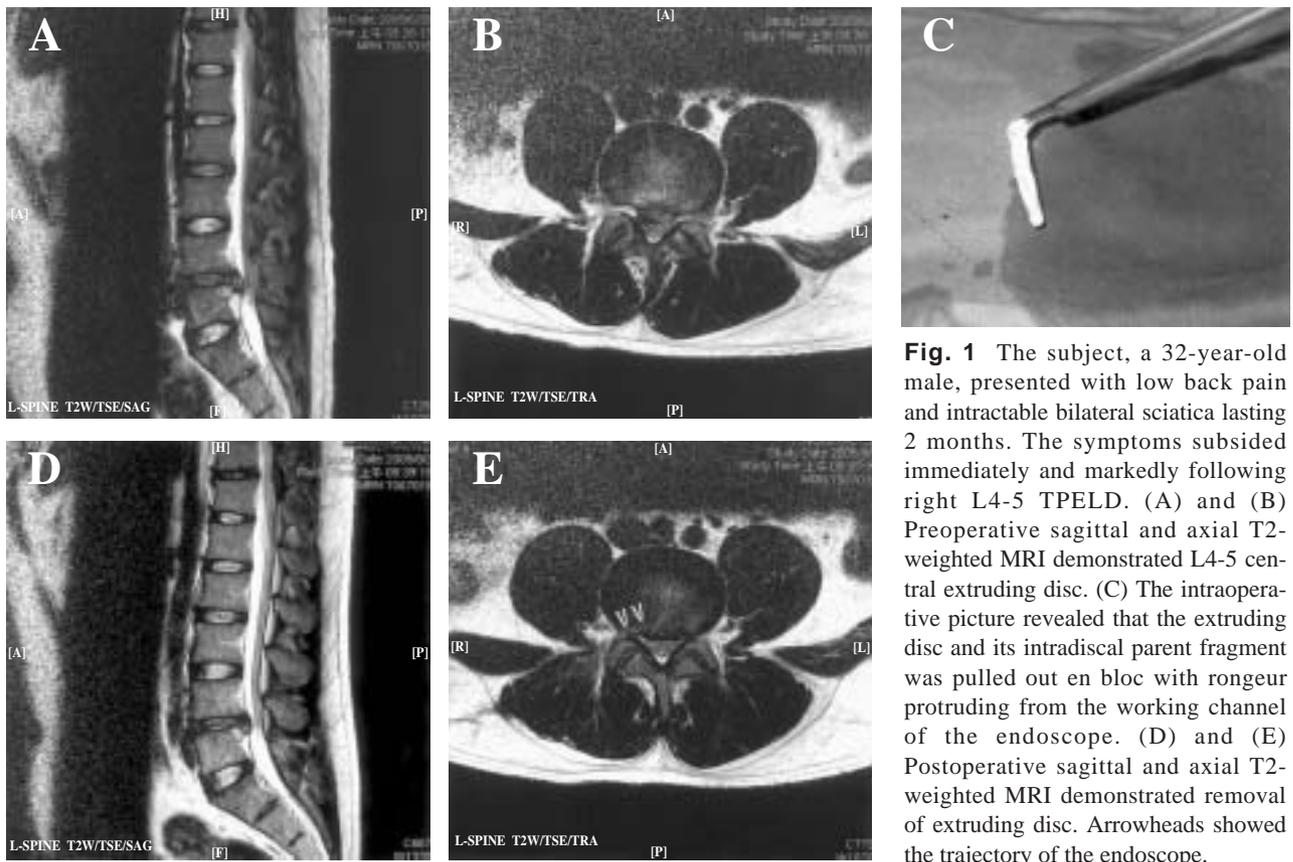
The subject, a 32-year-old male, presented with low back pain and intractable bilateral sciatica lasting 2 months. The symptoms subsided immediately and markedly following right L4-5 TPELD. (A) and (B) Preoperative sagittal and axial T2-weighted MRI demonstrated L4-5 central extruding disc. (C) The intraoperative picture revealed that the extruding disc and its intradiscal parent fragment was pulled out en bloc with rongeur protruding from the working channel of the endoscope. (D) and (E) Postoperative sagittal and axial T2-weighted MRI demonstrated removal of extruding disc. Arrowheads showed the trajectory of the endoscope.
